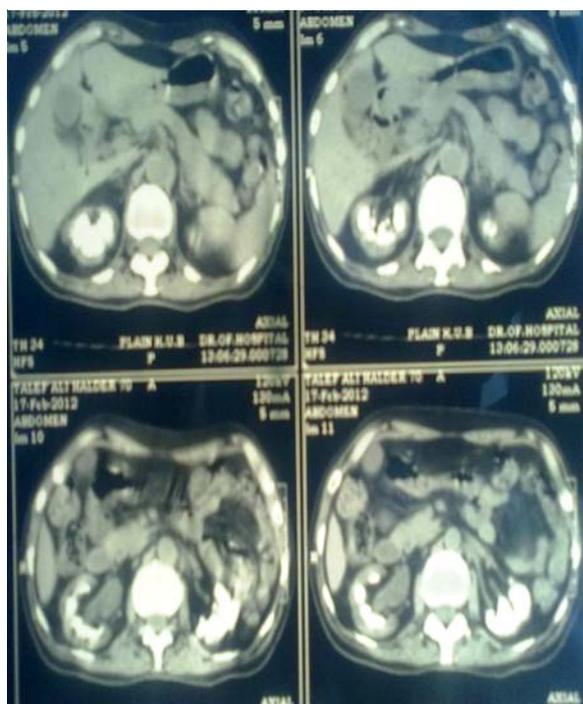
Non-contrasting CT scan showing extensive calcification in both the kidneys
